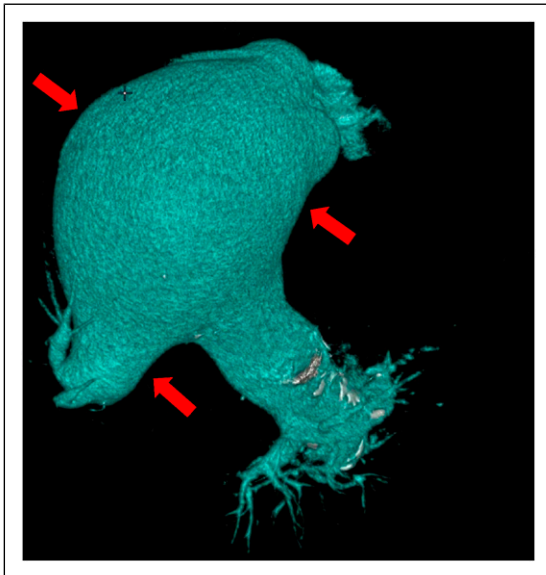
Three-dimensional reconstruction of the pulmonary artery trunk. The CT's 3D reconstruction reveals a pulmonary artery aneurysm with a maximum diameter extending from the trunk to its bifurcation, continuing as fusiform aneurysms on the right and left sides to their segmental branches. CT performed in 2023.
